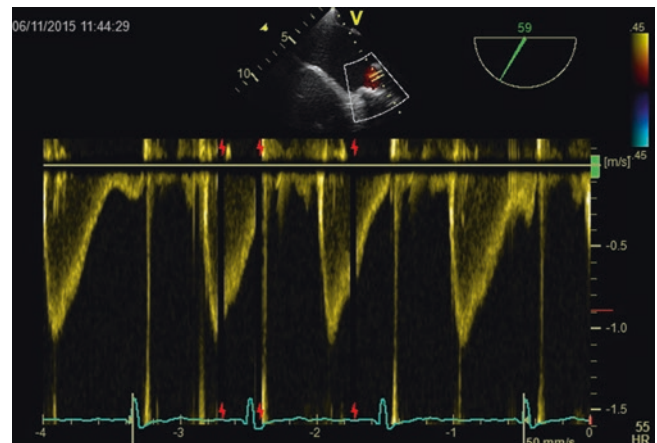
The Doppler inflow signal has normalized after Melody valve implantation into the stenotic homograft. A repeated TEE 14 months later shows good Melody valve function
